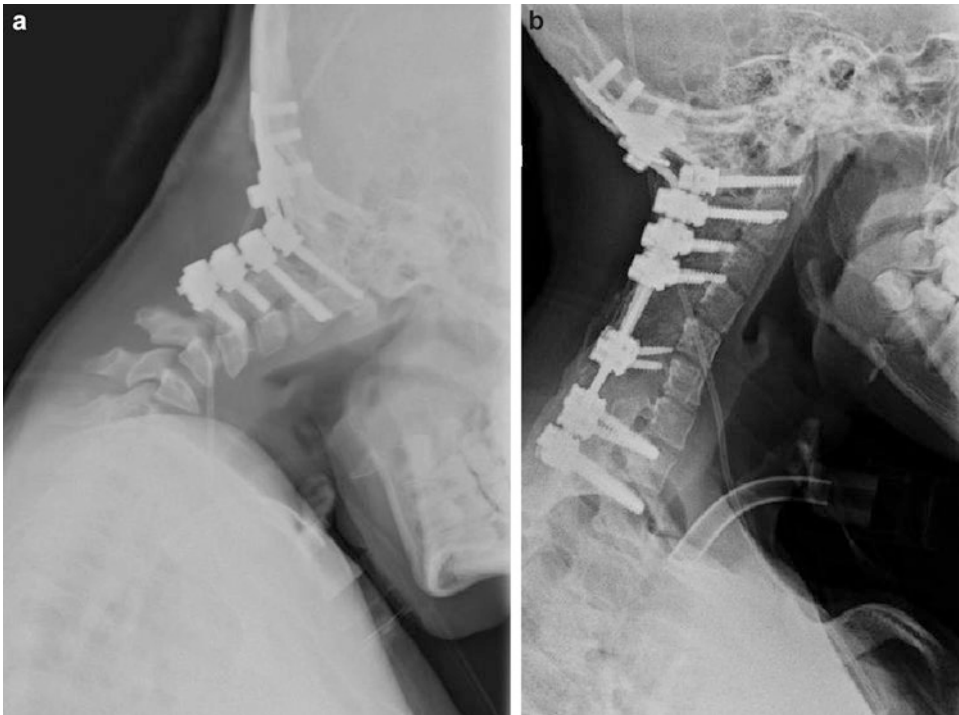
(a) Lateral radiograph of an 8-year-old child with junctional kyphosis after occiput to C4 fusion for traumatic occipitocervical dissociation and spinal cord
